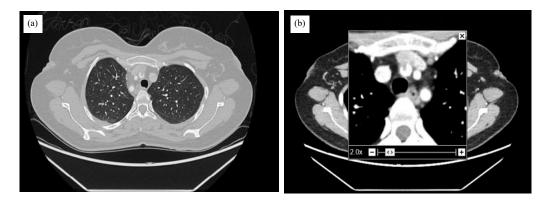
(a-b): CT Thoracic aorta showed filling defect of the right brachiocephalic artery in patient with crohn's disease having bluish discoloration of fingers
